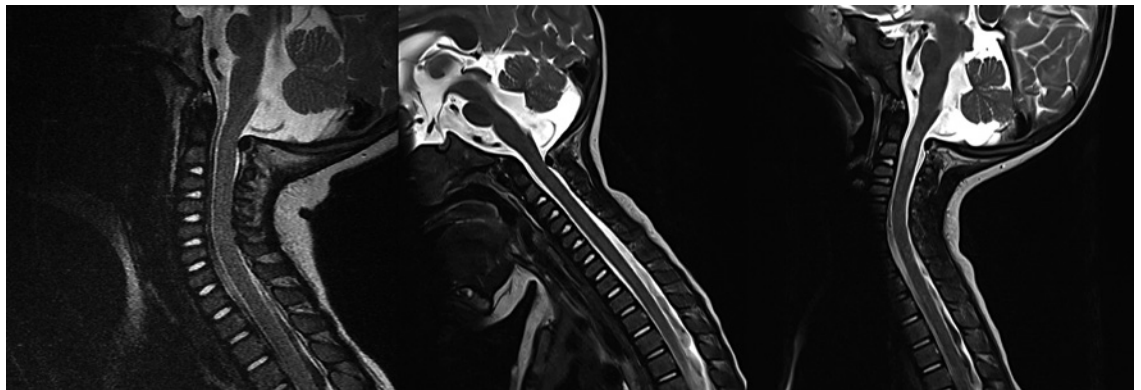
Example of stability on dynamic imaging. The left-sided figure is a static T2-weighted MRI in the sagittal plane. Initial review of this imaging was concerning for a hypoplastic arch of C1 resulting in upper cervical cord indentation. On dynamic imaging in flexion (center) and extension (right), the cord is seen to actually have reasonable space surrounding the cord and no significant dynamic instability or movement requiring operative intervention.
